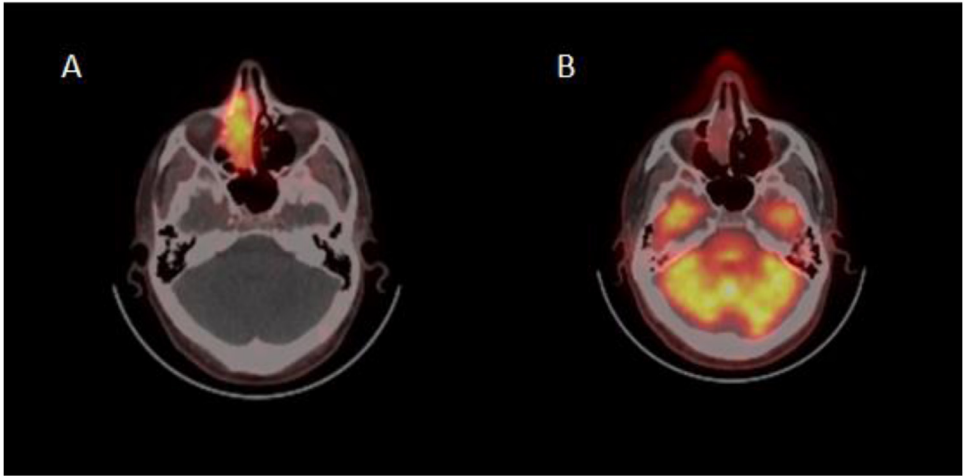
(A) Ga-68 DOTATATE image of nasal soft tissue mass (B) PET-CT scan of nasal soft tissue mass. (Color version of figure is available online.)
